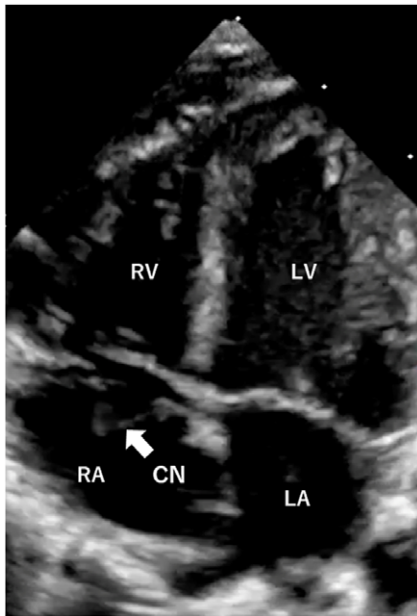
The apical four chambers view shows the Chiari network in the right atrium. CN: Chiari network, RA: right atrium, RV: right ventricle, LA: left atrium, LV: left ventricle.
